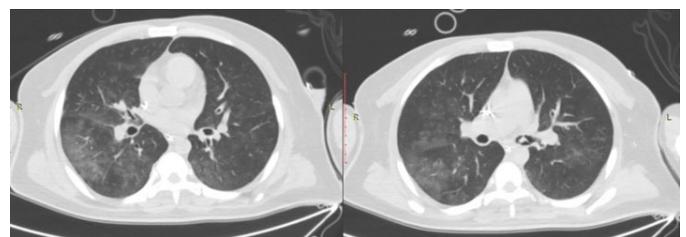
Non-contrast chest CT, lung window: bilateral ground-glass pattern, as well as hyperdensity in the left bronchus.
